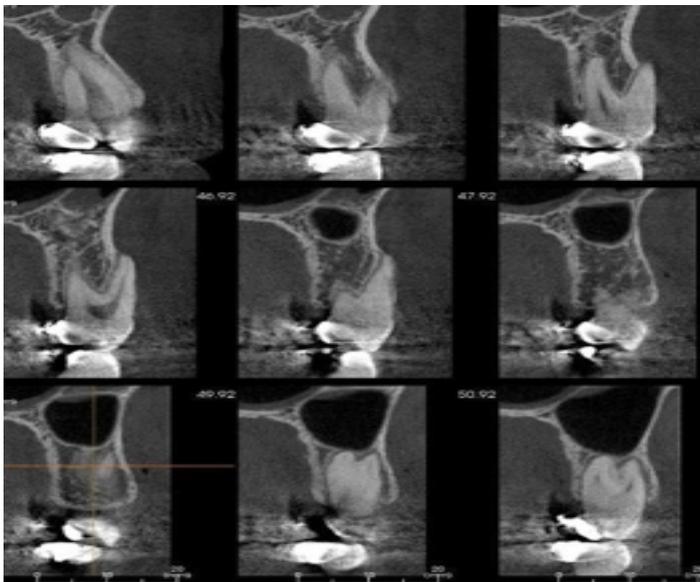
Progressive x-rays of the root problem incurred in the #17 from the CBT images.
